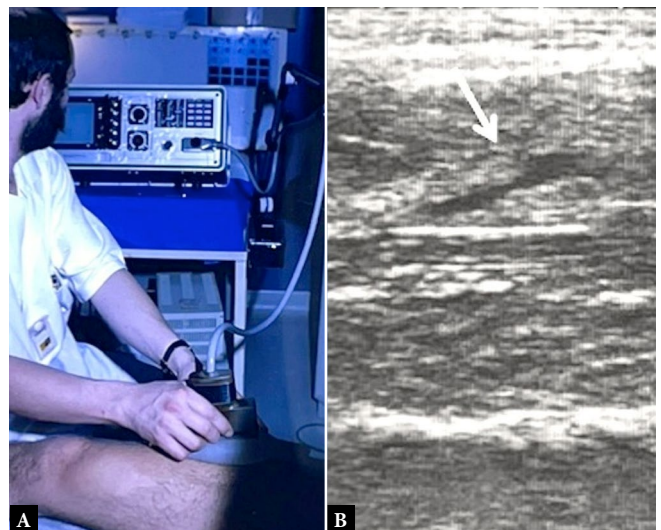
A. Early B-mode ultrasound scanner with first commercially available 5 MHz linear phased array transducer. Scans of the quadriceps muscles in a soccer player (1979–1980). B. Static image (1983) shows an obliquely oriented tear in the rectus femoris (arrow). Printed with permission of Dr. Bruno Fornage
